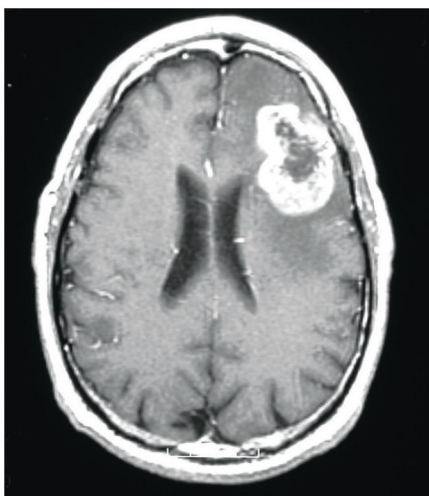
MRI image of a glioblastoma (from ABTA brochure [57])
